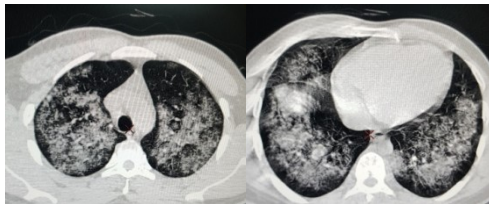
HRCT Chest at the time of arrival
